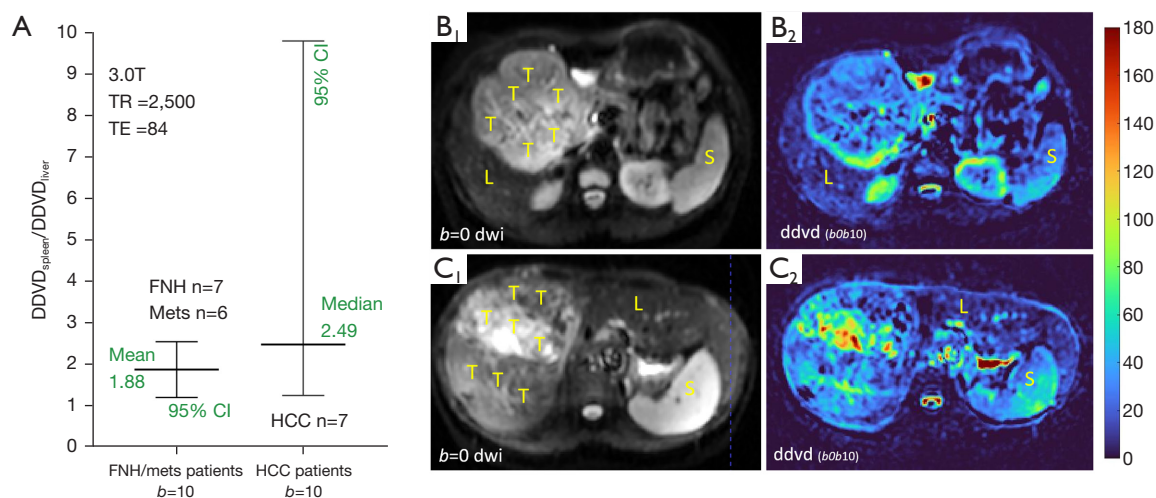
$DDVD_{spleen}/DDVD_{liver}$ ratio for data acquired with TE being 84 ms (TR =2,500 ms, acquired with respiratory gating) and 2nd b -value being 10 s/mm^2 . (A) Non-tumor regions of the liver were measured. (B,C) Two cases' DDVD maps calculated with $b=0$ and $b=10$ s/mm^2 DWI images, with spleen (S) showing higher signal than liver (L). T denotes the tumor regions. Unit for TR and TE is millisecond. CI, confidence interval; DDVD, diffusion-derived 'vessel density'; DWI, diffusion-weighted imaging; FNH, focal nodular hyperplasia; HCC, hepatocellular carcinoma; Mets, metastasis; TE, time of echo; TR, time of repetition.
